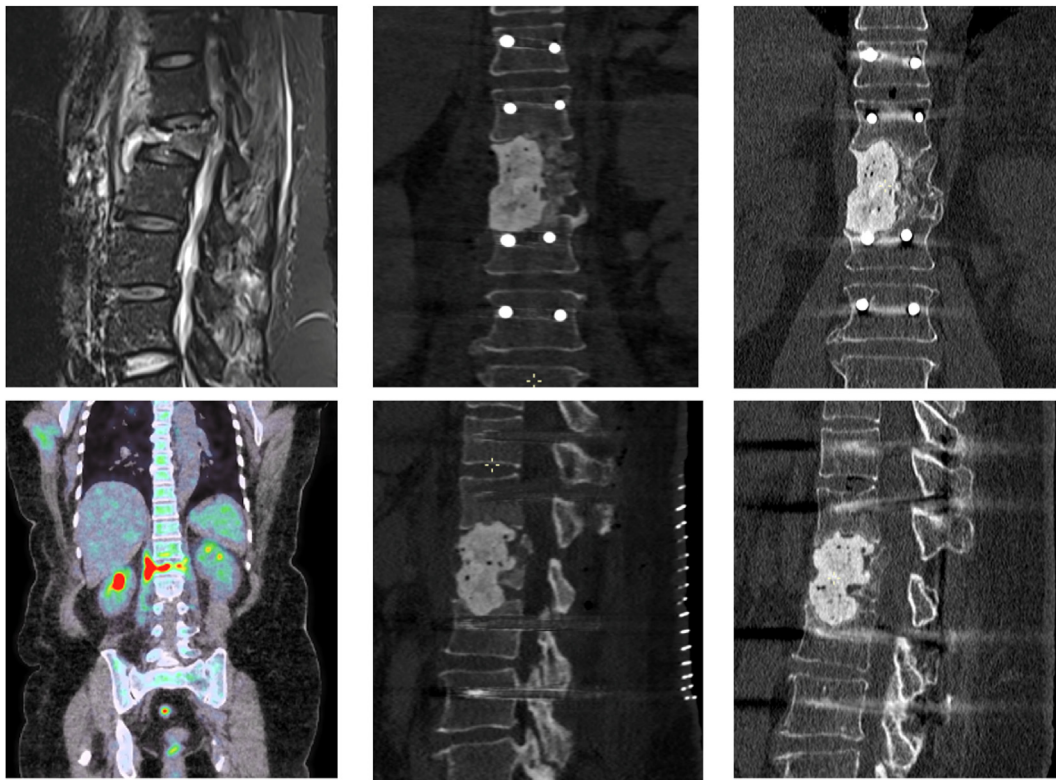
PMMA Cement was also used to reconstruct large defects. This 58-year-old woman had a streptococcus pyogenes septicemia with secondary spondylitis of L1, as diagnosed on the MRI (left, up) et PET-scan (left bottom). It was not possible to determine if the fracture happened before or after the infection. After one month of antibiotic treatment, surgery was performed for spinal instability. Posterior instrumentation was placed first, followed by anterior reconstruction with cement and grafts (middle up and bottom). At 2 years postoperatively, fusion is obtained, and cement is well tolerated. In coronal view, cement (right top) and in sagittal view (right down), bone can be seen very close to the cement and bone chips integration was very correct.
